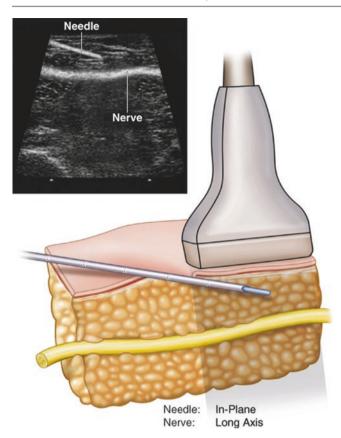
Long-axis imaging of the target nerve with needle advancement under in-plane ultrasound guidance
